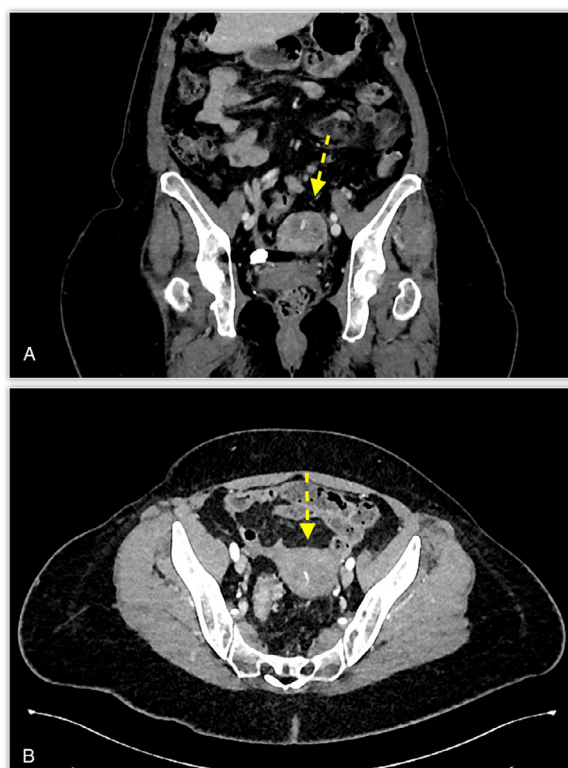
(A, B). The intra-uterine bleeding was visualized on CT using axial (A) images and on CT images was visualized curved coronal MPR (B) (yellow arrows).
